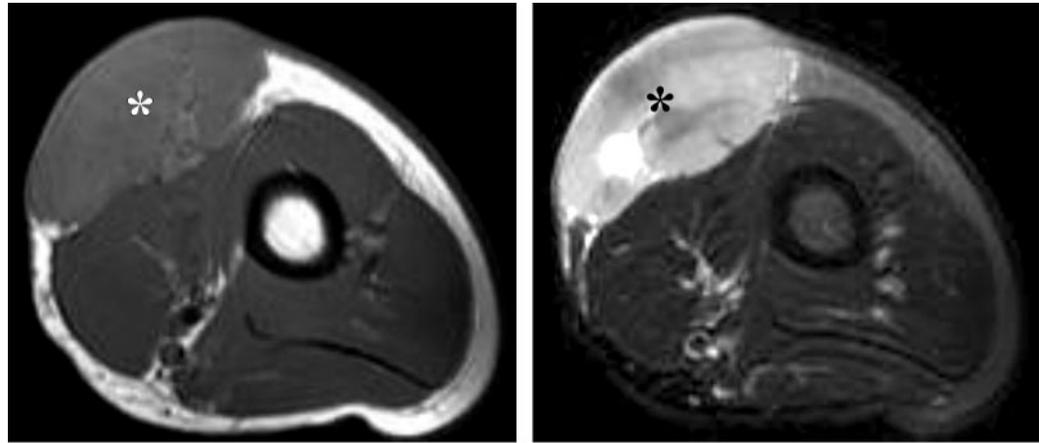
Superficial B cell lymphoma in the forearm of a 53-year-old man. Axial T1-weighted (716/9) (a) and axial T2-weighted (2350/80) fat-suppressed (b) SE MR images show a large homogeneous mass (*) with nonspecific features in the cutaneous and subcutaneous compartments. The mass demonstrated signal intensity slightly higher than that in skeletal muscle at T1-weighted imaging, high signal intensity at T2-weighted imaging, and intense homogeneous enhancement at gadolinium-enhanced MR imaging.
